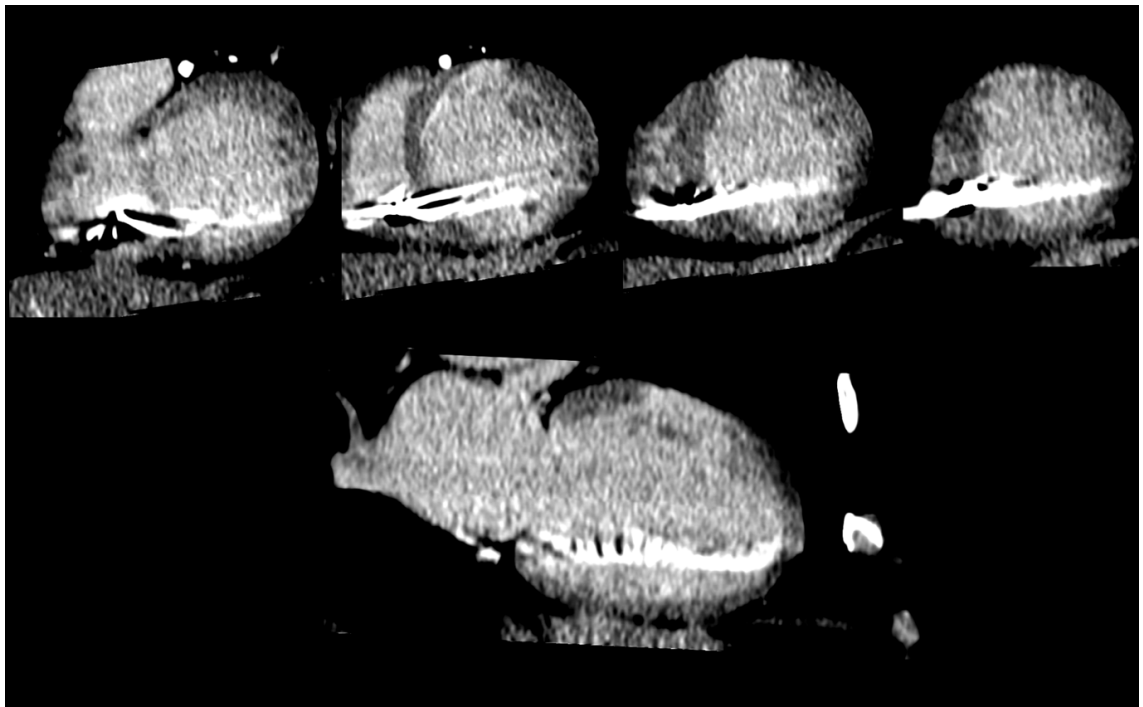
Late iodine enhancement seen with single energy cardiac CT (protocol B)
